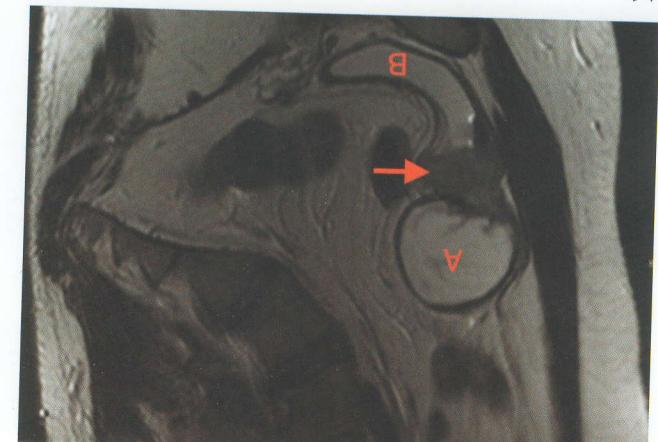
MRI scan. A. Urachal Tumor, B. Bladder, Arrow - Invasion of the urachal tumor into the bladder
